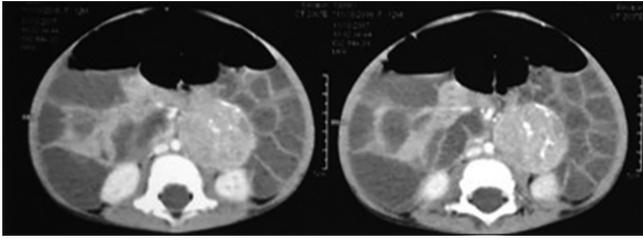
Computed tomography abdomen showing heterogeneous mass lesion with calcification in the left para-aortic region
